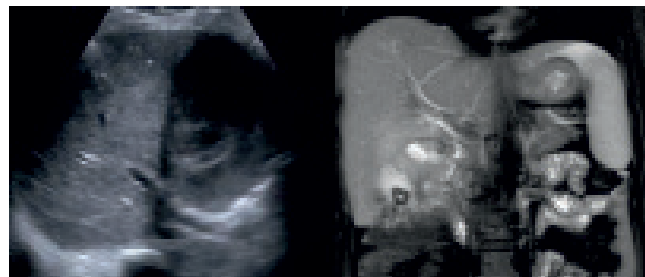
USG (left) and MRI (right) images of adherent GB in same patient showing necrosis of wall, intraluminal sludge, cholelithiasis and subhepatic abscess
